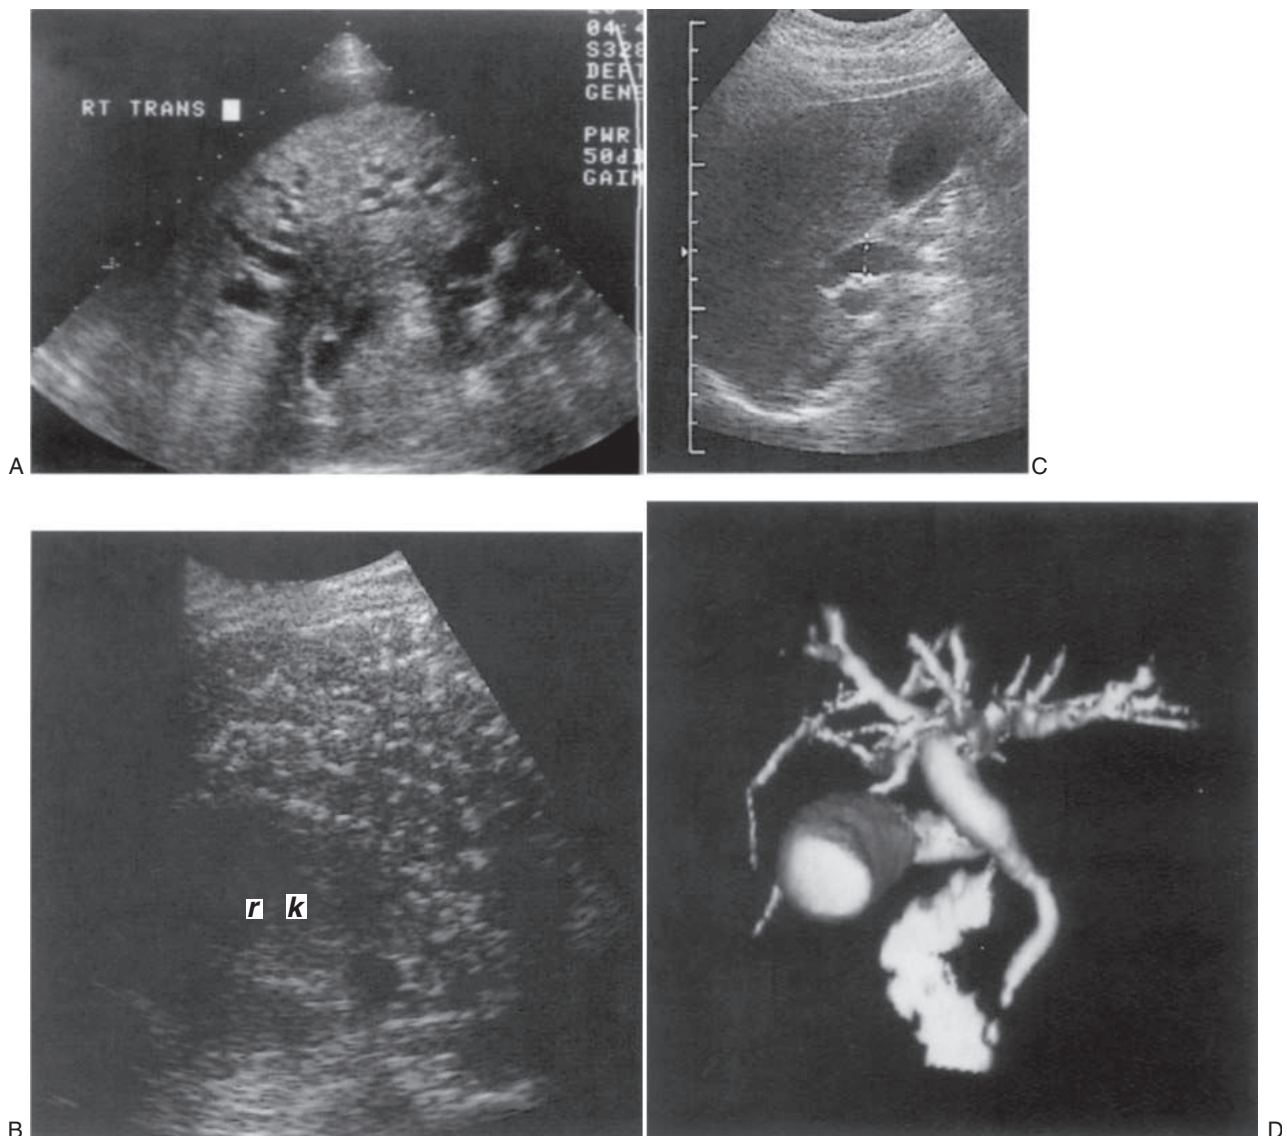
Caroli's disease. (A) Dilated biliary tree and ascites. (B) TS of a different patient with end-stage disease. The grossly abnormal liver texture contrasts with the right kidney. (C) A small section of focal CBD dilatation persisted in a symptomatic patient, with normal-calibre distal CBD. This was confirmed on ERCP and thought to be a dyskinetic segment, causing biliary reflux, but was later diagnosed as a mild form of Caroli's. (D) 3D CT reconstruction of the case in (C), confirming the ultrasound appearances. Note the tiny ectatic 'pouchings' of the intrahepatic ducts characteristic of Caroli's.
